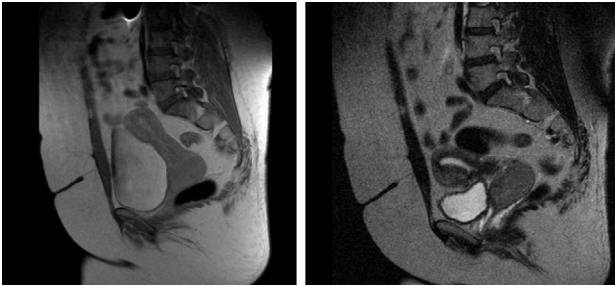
Sagittal MRI section of the pelvis showing an expansive lesion in the uterine cervix, ovoid, in continuity with the vaginal vault, without evidence of involvement of the parametrium and regional lymph nodes.
